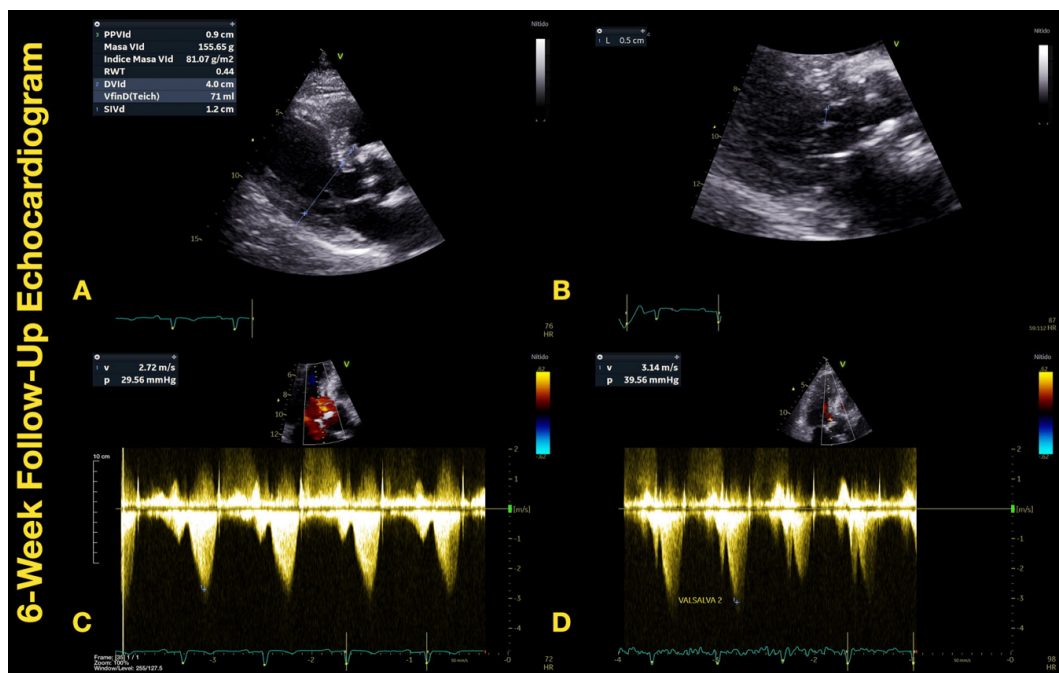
Six-week follow-up echocardiogram. A. Septal thickness (12 mm) and indexed left ventricular mass (81 g/m²); B. Coaptation-to-septum distance (5 mm); C. Resting peak gradient (29.6 mmHg); D. Valsalva peak gradient (39.6 mmHg).
